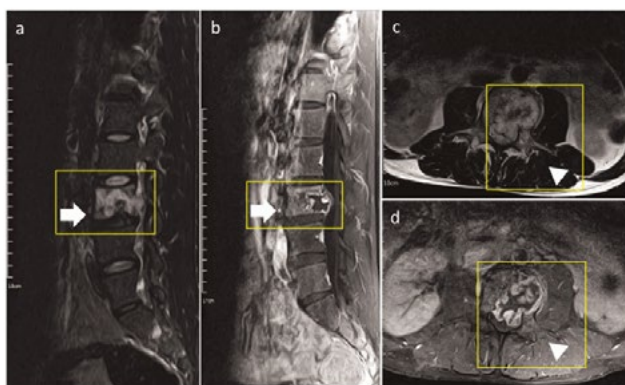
MRI of the Lumbar Spine
